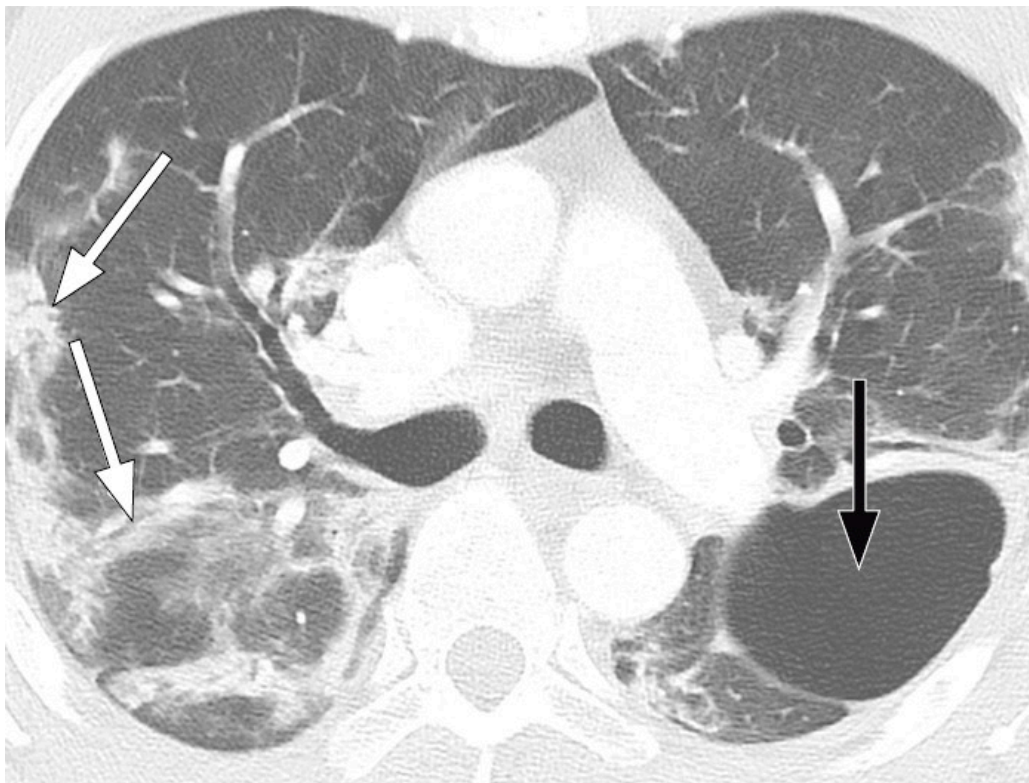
Patient with COVID-19. Chest CT 20 days after symptom onset shows bilateral opacities with peripheral and peribronchovascular distribution. Bronchiectasis (white arrows) and an air-filled cavity (black arrow) in the left lung provide evidence of organisation.
